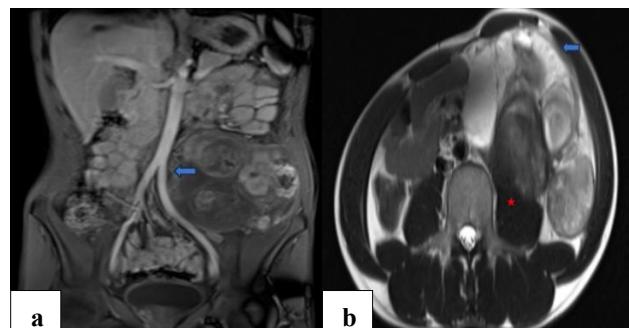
MRI images showing the relationship and extension of the mass (a) coronal T1WI post-contrast image shows the mass abutting the aorta and causing its medial displacement (blue arrow); however, no vascular invasion is seen. It is displacing the bowel loops superiorly and to the right side, and (b) axial T2WI MR image shows focal loss of fat plane with left psoas (red asterisk). It is abutting the anterior abdominal wall anteriorly (blue arrow).
